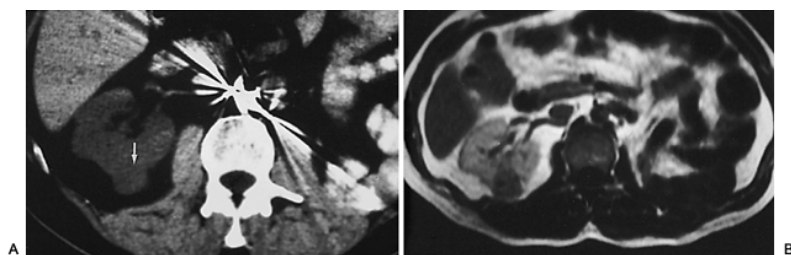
1. A 47-year-old patient with prior nephrectomy for renal cell carcinoma and a severe contrast allergy. A: Noncontrast computed tomography (CT) scan 2 years after nephrectomy demonstrated a nonspecific bulge in the posterior kidney (*arrow*). Because intravenous iodinated contrast media could not be given, a magnetic resonance imaging (MRI) scan was performed with gadolinium. B: An enhancing mass corresponding to the lesion seen on CT that proved to be a recurrent renal cell carcinoma.
